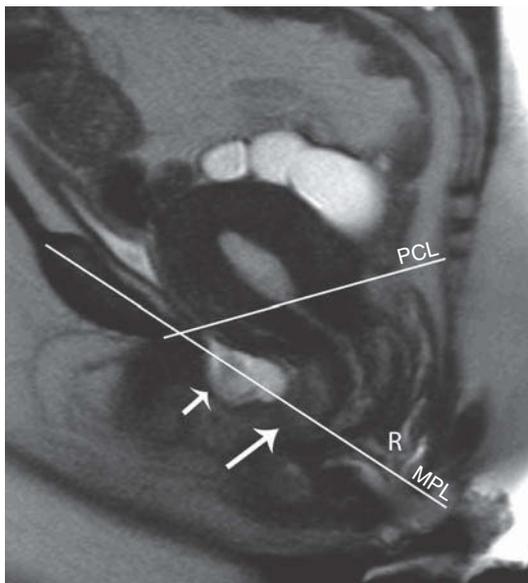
Global pelvic prolapse in a 46-year-old female. Sagittal T2-weighted SSFSE image obtained during Valsalva maneuver reveals descent of the bladder (short arrow) and the uterus (long arrow) below both the midpubic line (MPL) and the pubococcygeal line (PCL). The bladder base is 1.5 cm below the MPL and 4.5 cm below the PCL corresponding to Stage 3 or moderate bladder prolapse. The anterior cervical lip is 1.3 cm below the MPL and 5.5 cm below the PCL corresponding to Stage 3 or moderate uterine prolapse. Also note rectal descent (R), although evaluation of the rectum is limited on this image as the rectal contrast material has already been evacuated.
